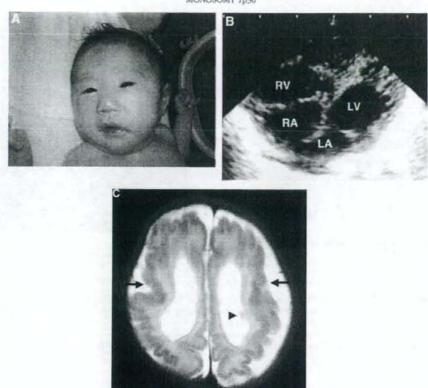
A: Patient at age 27 days. B: A four-chamber view echocardiogram. Numerous prominent trabeculations and intertrabecular recesses in the apex and free wall of the left ventricel indicate left ventricular noncompaction. Apical displacement of the septal leafler of the tricuspid valve from insention of the anterior leafler of the mitral valve indicate Ebstein's anomaly. RA, right attrium: RV, right ventricle: LA, left attrium: LV, left ventricle: CA, at Z-weighted axial magnetic resonance image. Bilateral perisyivian polymicrogyria is shown as irregularly small and fused gyri, separated by shallow sulci, and cortical thickness (5 mm) from the perisyivian regions to the frontal lobes (arrows). A periventricular notical hat heterotopia is shown as a leasion protructing from the well of the left lateral ventricle with isointensity as gray matter (an arrowhead). Bilateral ventricles are enlarged. [Color figure can be viewed in the online issue, which is available at www.interscience. witey.com.]
